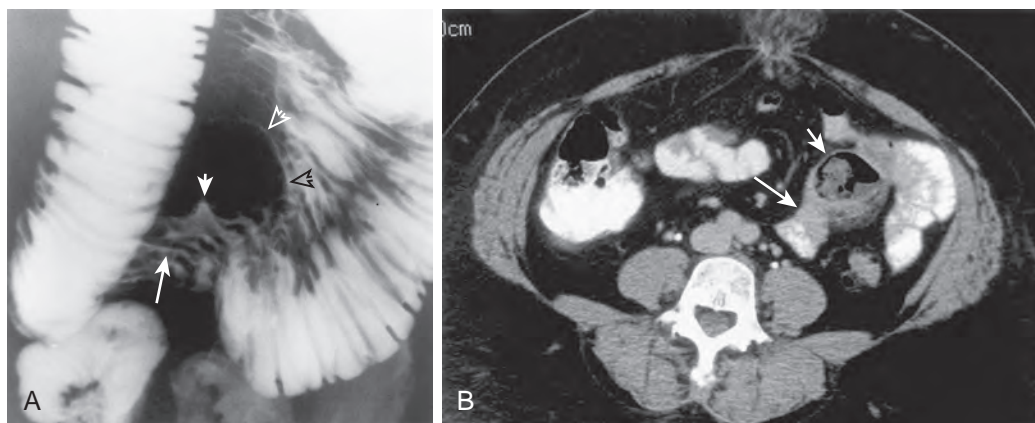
Ectopic pancreas in the jejunum complicated by pancreatitis and pseudocyst formation. A. Enteroclysis shows a tiny barium collection (short arrow) in the jejunum. Small bowel folds in this region are mildly thickened and undulating (long arrow) and are parallel to the longitudinal axis of the bowel rather than straight and perpendicular to the bowel, as seen in the normal adjacent jejunum. Mass effect (open arrows) is also seen at the edge of the lesion. B. CT scan shows a soft tissue mass (long arrow) replacing the contrast-filled lumen of the bowel. A central cavity (short arrow) contains air and soft tissue. At pathology, the soft tissue mass was ectopic pancreatic tissue with associated pancreatitis, and the cavity was a pseudocyst that communicated with the lumen. This lesion could easily be confused with jejunal diverticulitis or a cavitory mass, such as lymphoma.
